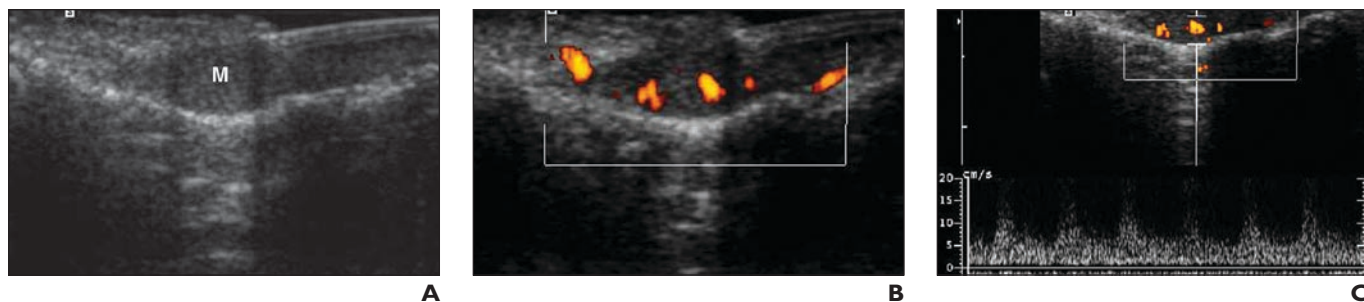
40-year-old woman with thumb pain. MRI was nondiagnostic.
